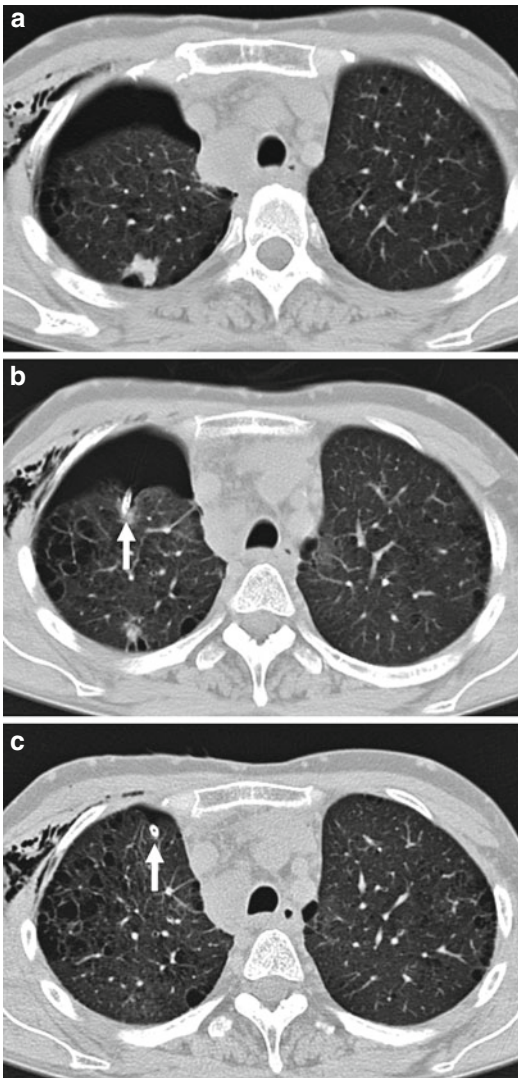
Patient with severe emphysema and coin lesion in the right upper lobe developed pneumothorax after biopsy (a). Due to dyspnea, a catheter (arrow) with Heimlich valve was inserted on the CT table (b). Five minutes after insertion of the catheter, the pneumothorax was completely resolved (c)
